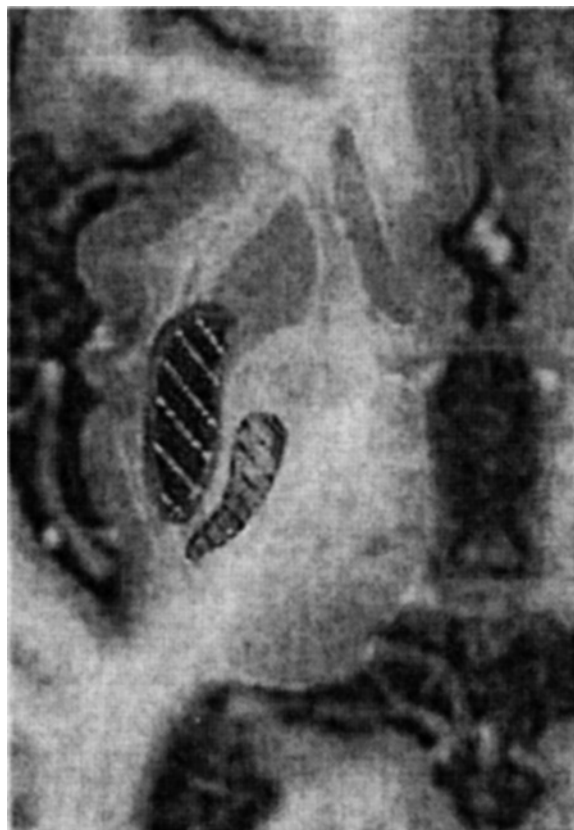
Brain MRI scan depicting surgical lesion in the posterior limb of the internal capsule abolishing central post-stroke pain. From Koszewski *et al.* 2003, with permission from VSP, an imprint of Brill Academic Publishers.
